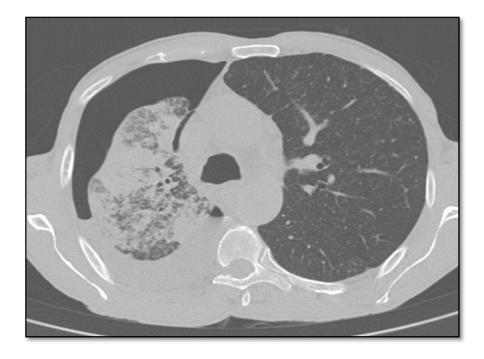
Plain CT axial section showing moderate right hydropneumothorax with suspicious broncho-pleural fistula in patient with tuberculosis
